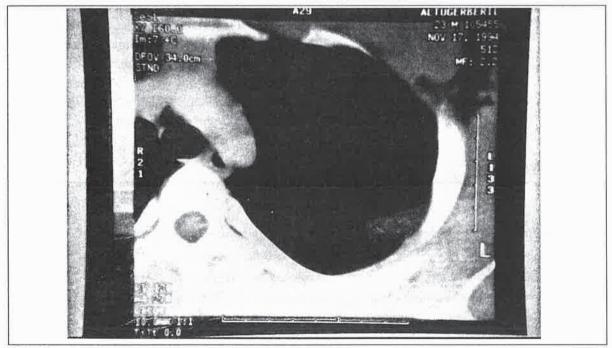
CT scan revealing a pleural-based mass in the left hemithorax
